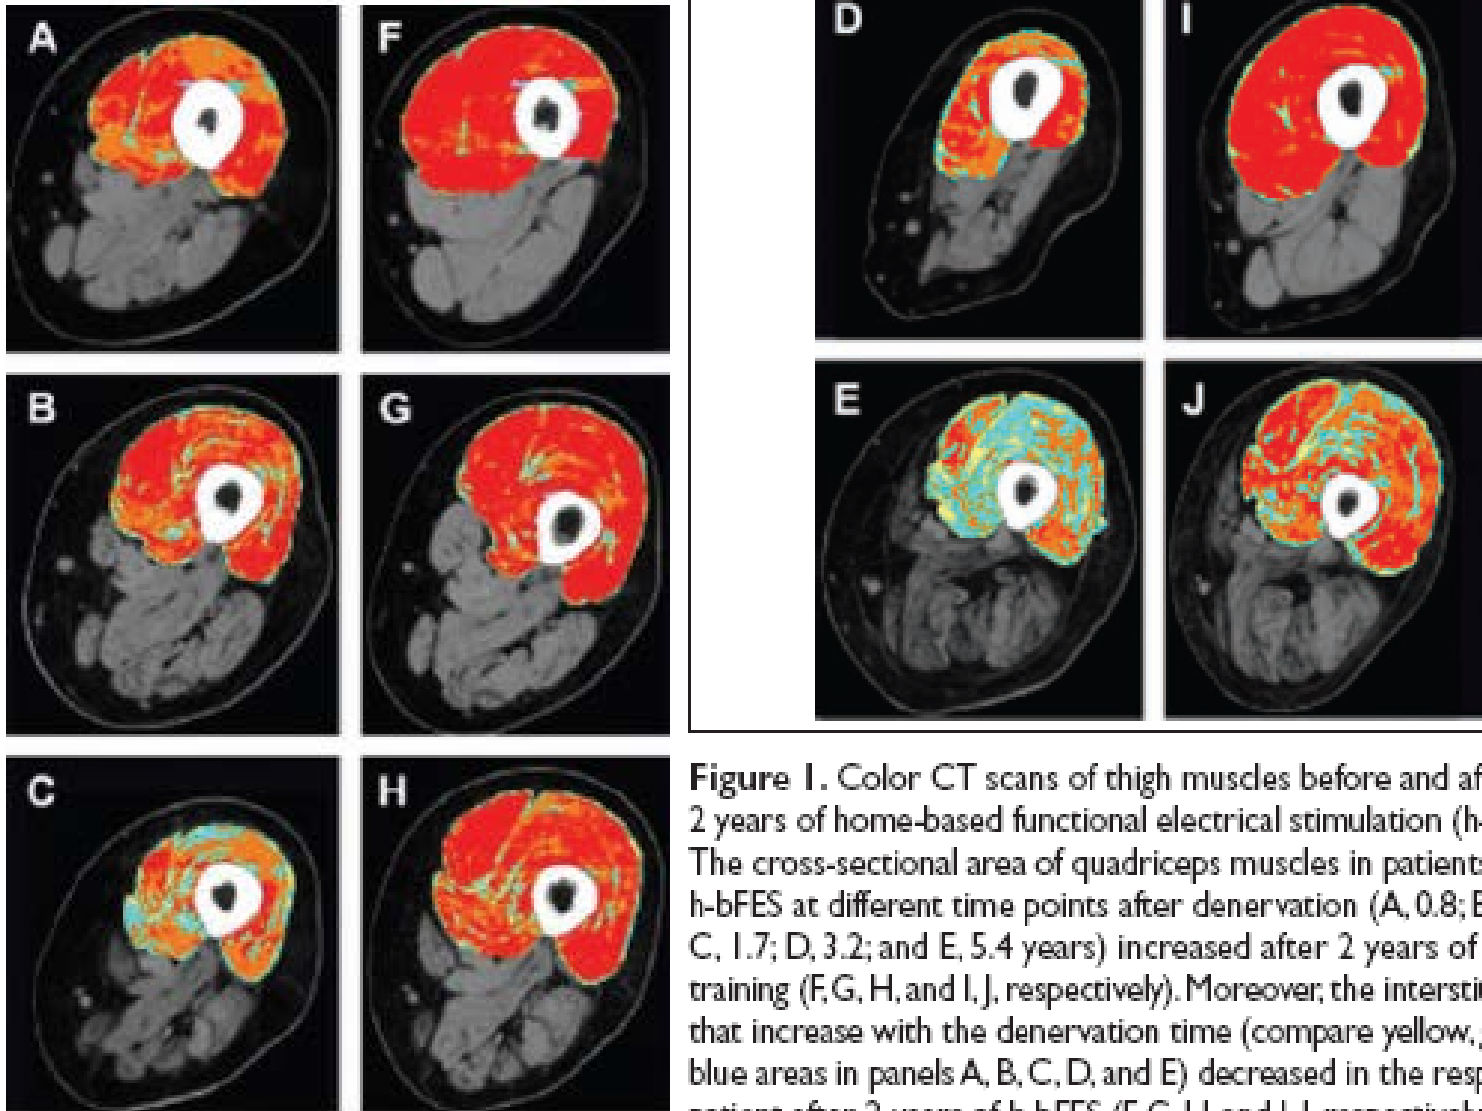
Color CT scans of thigh muscles before and after 2 years of home-based functional electrical stimulation (h-bFES). The cross-sectional area of quadriceps muscles in patients starting h-bFES at different time points after denervation (A, 0.8; B, 1.2; C, 1.7; D, 3.2; and E, 5.4 years) increased after 2 years of home training (F, G, H, and I, respectively). Moreover, the interstitial tissues that increase with the denervation time (compare yellow, green, and blue areas in panels A, B, C, D, and E) decreased in the respective patient after 2 years of h-bFES (F, G, H, and I, respectively)
